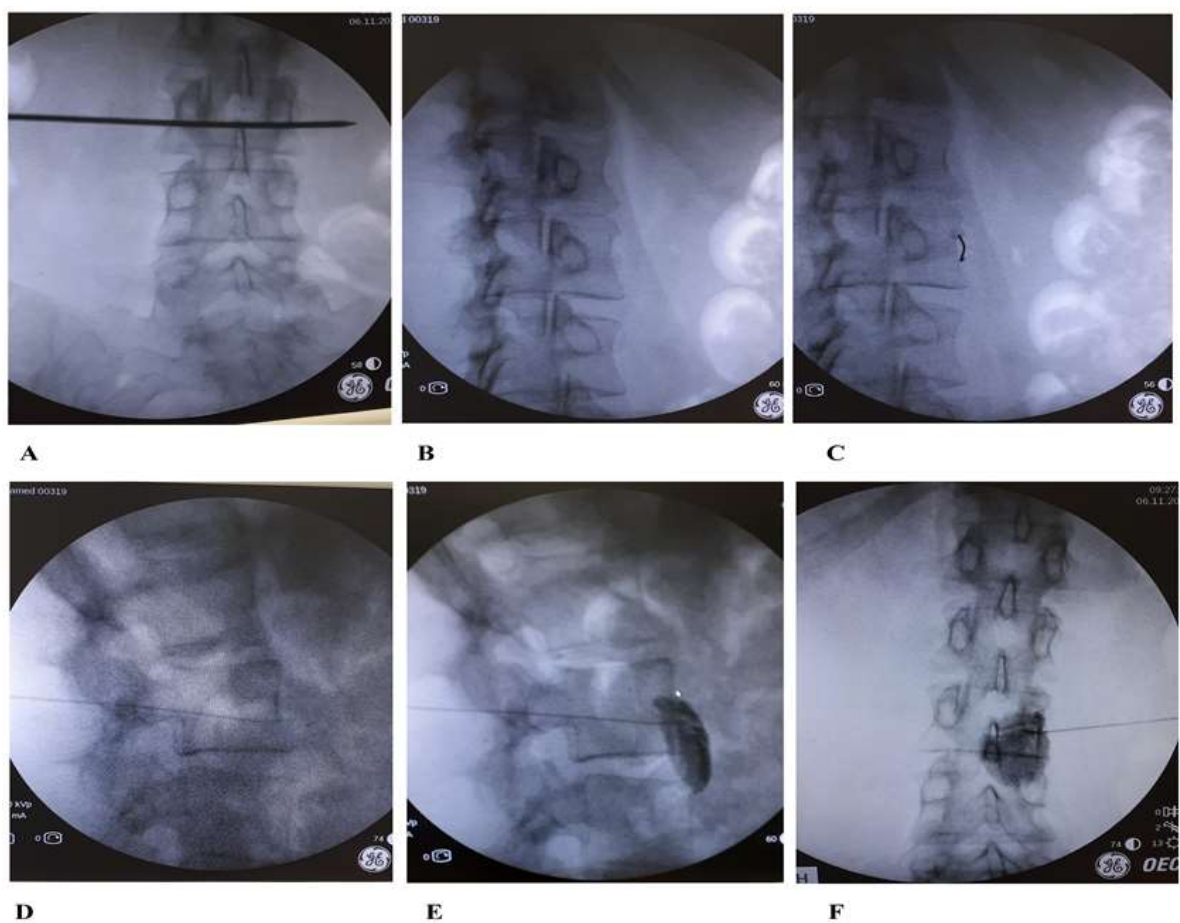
X-ray navigated lumbar sympathetic blockade in P-A projection, oblique projection and lateral projection A: endplate alignment of the target vertebra, B: C-arm rotation into oblique projection, C: needle insertion, D: needle control in lateral projection, E: contrast propagation in lateral projection, F: contrast propagation in A-P projection (from the author's archive).
